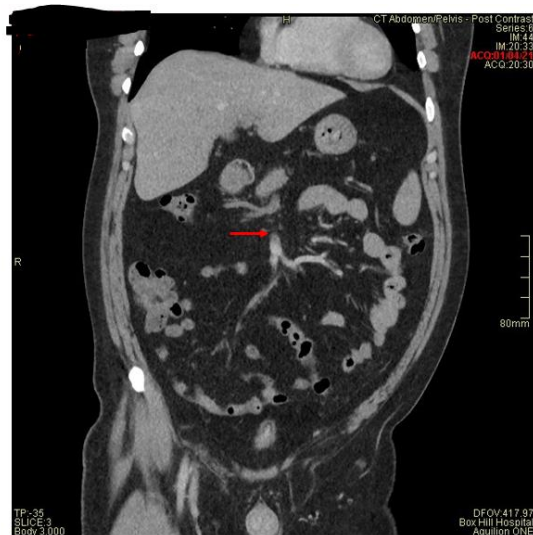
CT-venogram at presentation showing filling defect of portal vein, contrast in superior mesenteric vein and its tributaries (red arrow, coronal plane)
